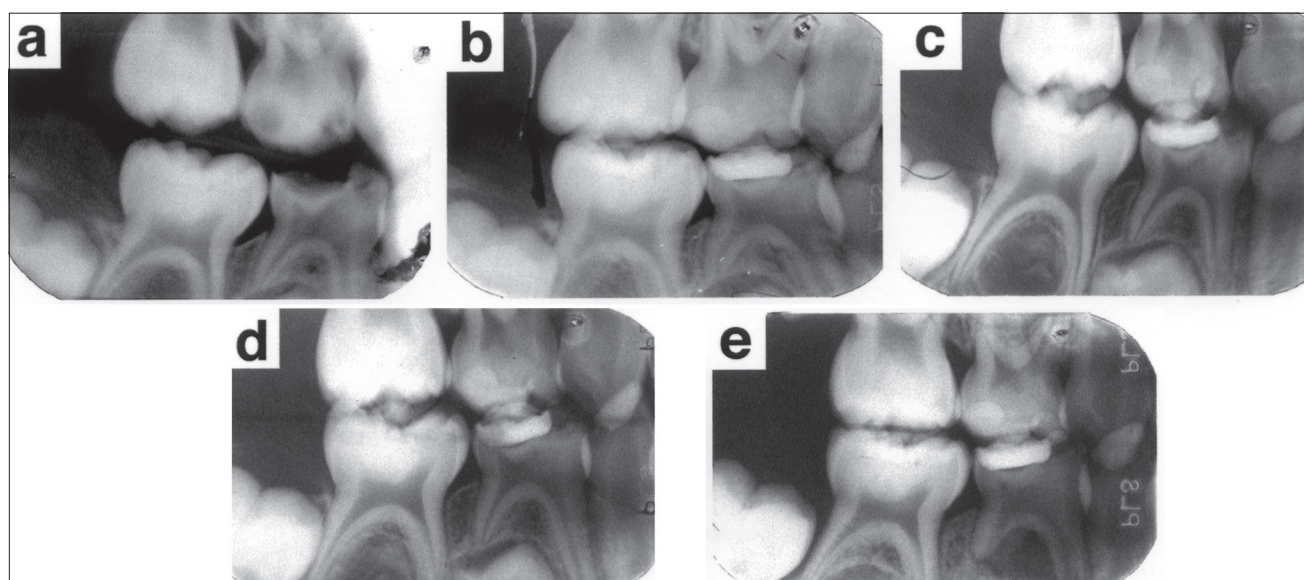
Radiographic evaluation of a mandibular first primary molar that received indirect pulp treatment with adhesive resin only and was considered a failure after 18 months. Preoperative radiograph (a), immediate postoperative (b), and 6 months (c), 12 months (d) and 18 months (e) after indirect pulp treatment. The interradicular lesion accompanied by external and internal root resorption observed in panel (e) was indicative of treatment failure.
